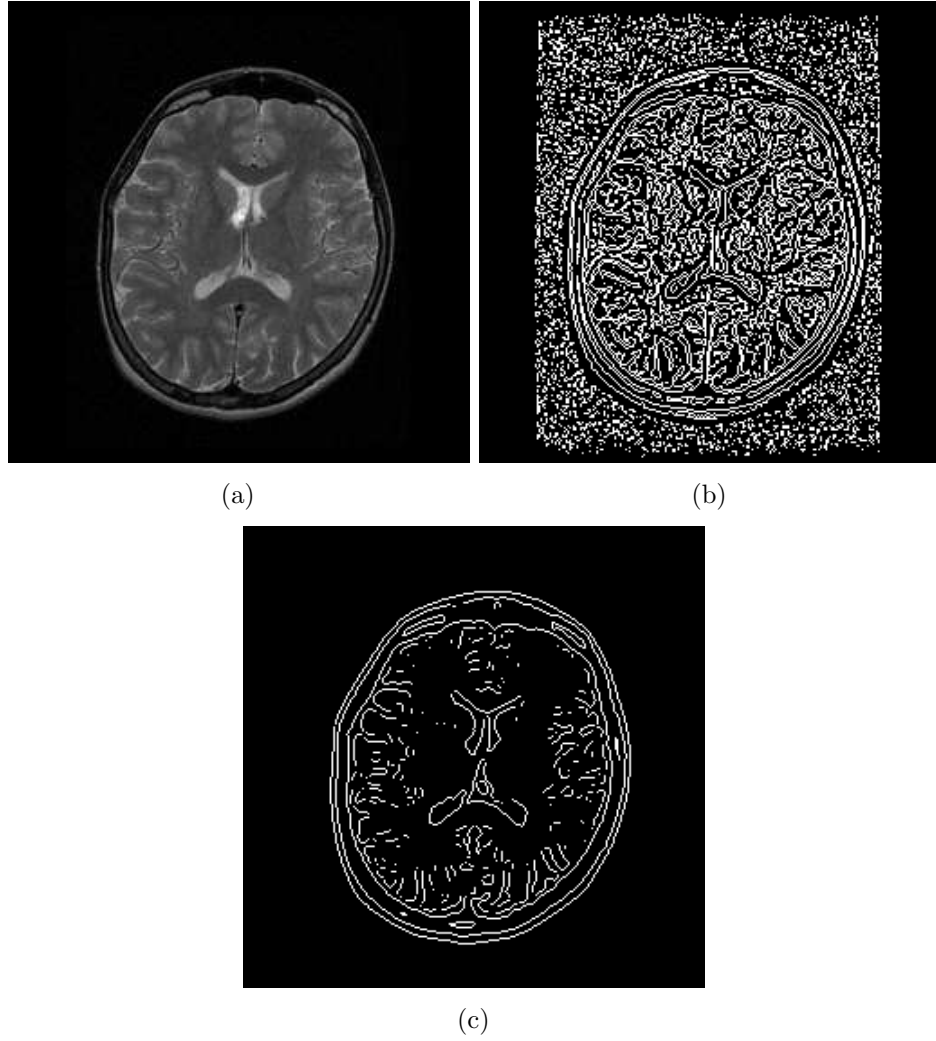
Effect of Standard Deviation ( $\sigma$ ) parameter on the identification of edges via Laplacian of Gaussian method. (a) Original T2-weighted MR image (b)  $\sigma = 1$  (c)  $\sigma = 2$
